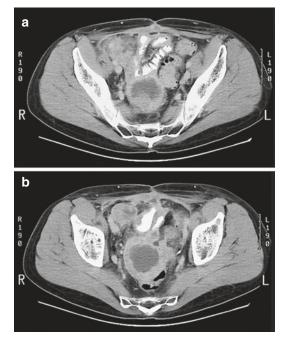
Extraskeletal Ewing's sarcoma of the pelvis in a 36-year-old man. (a) CT after iodinated contrast injection. (b) Section at a lower level than in (a). Hourglass-shaped soft tissue tumor in the pelvis, with major tumor component in a right anterolateral position to the rectum and smaller component anteriorly in the right iliac fossa. Ill-defined, hypodense area without enhancement within the major tumor component, suggesting a necrotic center of the tumor (a). Necrotic areas within both tumor components are more clearly seen at the caudal section (b). Sequel from previous laparotomy and thickening of bowel walls following radio-therapy are observed at both levels
